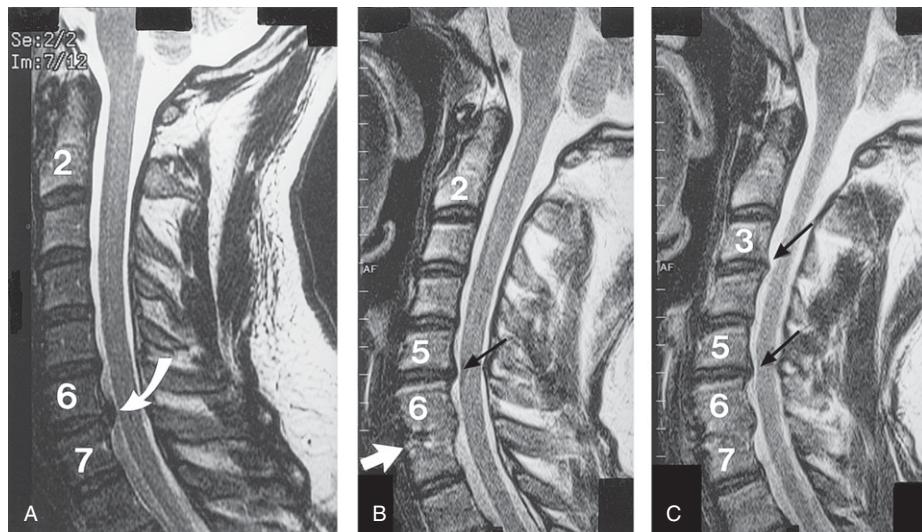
(A) Cervical spine MRI sagittal T2-weighted image. The numbers represent the vertebral body level and the curved arrow shows the large C6–7 disc protrusion that considerably indents the pain-sensitive anterior surface of the dural tube and almost touches the spinal cord itself. (B, C) Cervical spine MRI sagittal T2-weighted images. The numbers represent the vertebral bodies and the white arrow shows where surgery was performed at the C6–7 level. The black arrows show the disc protrusions at the C3–4 and C5–6 levels, respectively. Note how the disc protrusions indent the pain-sensitive anterior surface of the dural tube.
